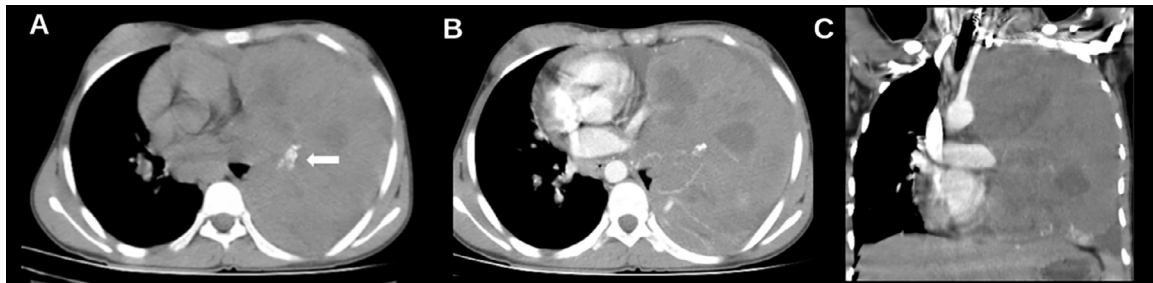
(A) Precontrast axial chest CT revealing a well-defined, predominantly soft tissue attenuating mass lesion in the left hemithorax with an irregular calcific focus (white arrow). (B, C) Postcontrast axial and coronal reformatted chest CT images demonstrating a well-margined, heterogeneously enhancing left thoracic mass with cystic components.
